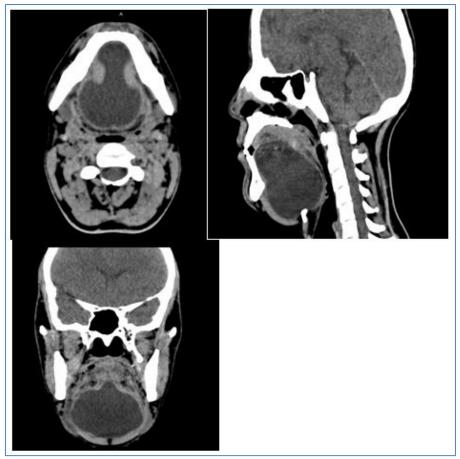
CT scan (axial, sagittal and coronal) showing elevated base of tongue with compromised oropharyngeal airway due to giant dermoid cyst floor of mouth
